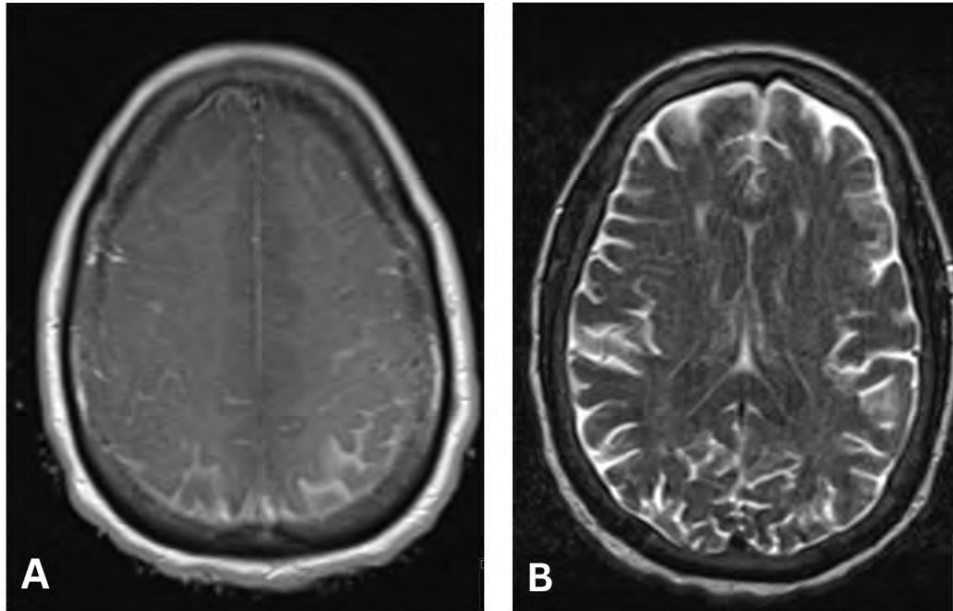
Case of a 58-year-old female with a history of T-spine epidural mass s/p laminectomy and decompression who was admitted for concern for cord edema and dysarthria. A) Axial pre-contrast T1-weighted and B) Axial FLAIR images demonstrate intrinsic T1 hyperintensity involving sulci/subarachnoid spaces with diffuse sulcal CSF FLAIR non-suppression.
